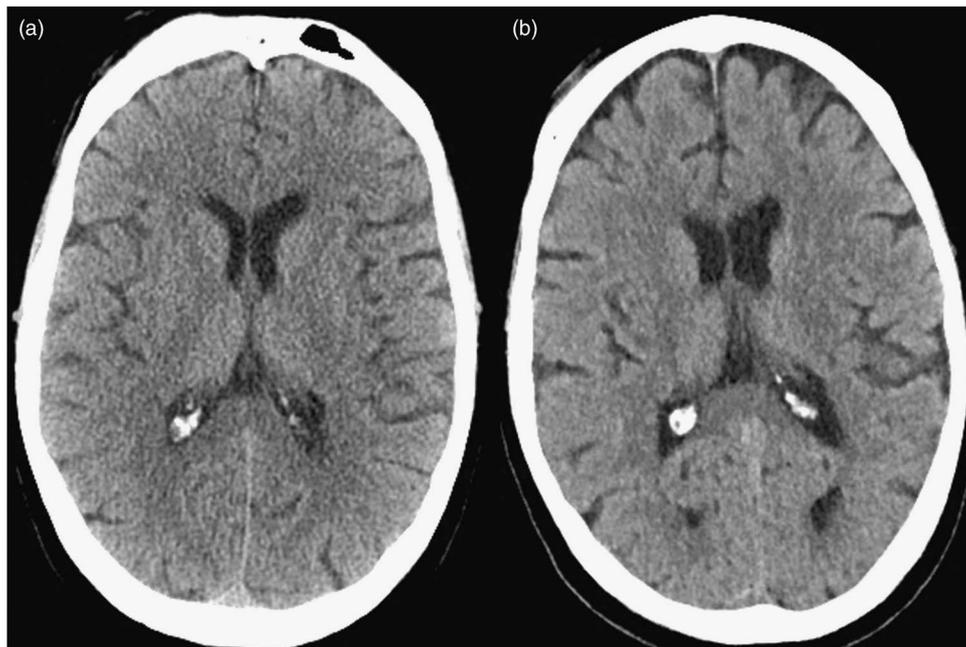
A 41-year-old man with a seizure disorder. (a) Axial noncontrast head CT image (width, 80 HU; level, 40 HU) reconstructed with FBP from a raw CT dataset acquired with a tube current of 300 mAs. (b) Axial noncontrast head CT image (width, 80 HU; level, 40 HU) reconstructed with SAFIRE from a raw CT dataset acquired with a tube current of 247 mAs. The scans were performed 1 month apart.
